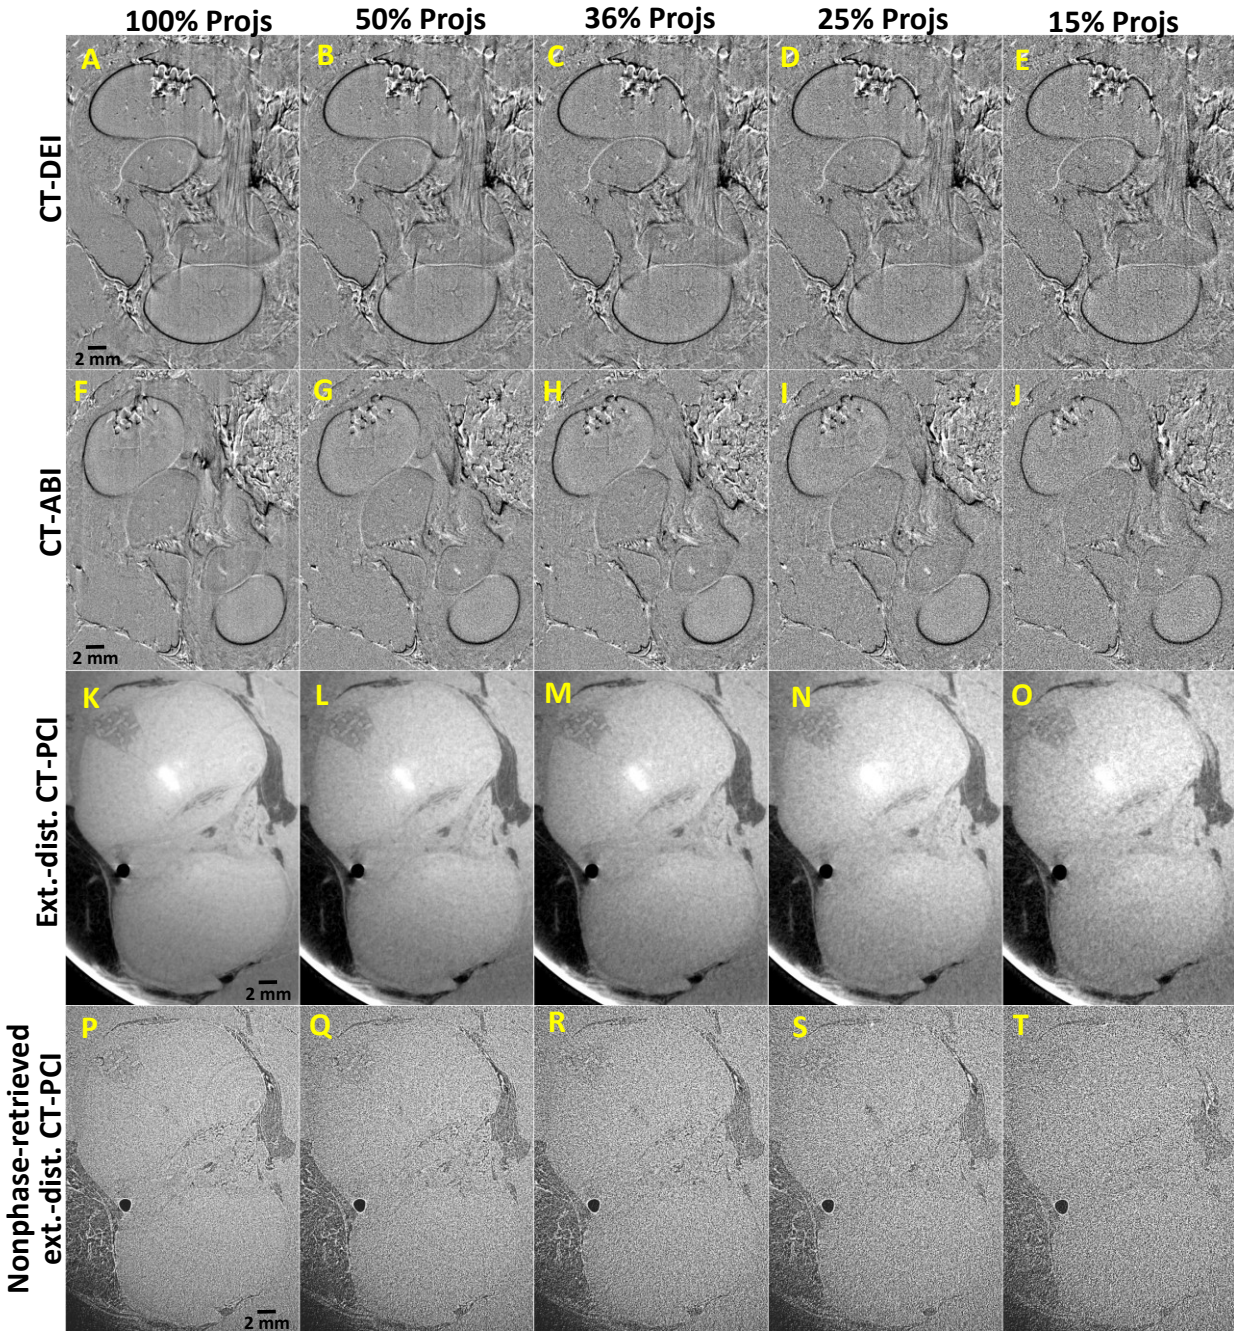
Qualitative image comparison in CT phase-based imaging using a lower number of projections. (A–E) CT-DEI, (F–J) CT-ABI, and (K–O) phase-retrieved and (P–T) nonphase-retrieved extended-distance (ext.-dist.) CT-PCI at (A, F, K, P) 100%, (B, G, L, Q) 50%, (C, H, M, R) 36%, (D, I, N, S) 25%, and (E, J, O, T) 15% of the standard number of projections. The bright spot visible in panels (K–O) corresponds to the start of the ossification center, and are better visualized in the phase-retrieved images than the nonphased retrieved images (P–T).
